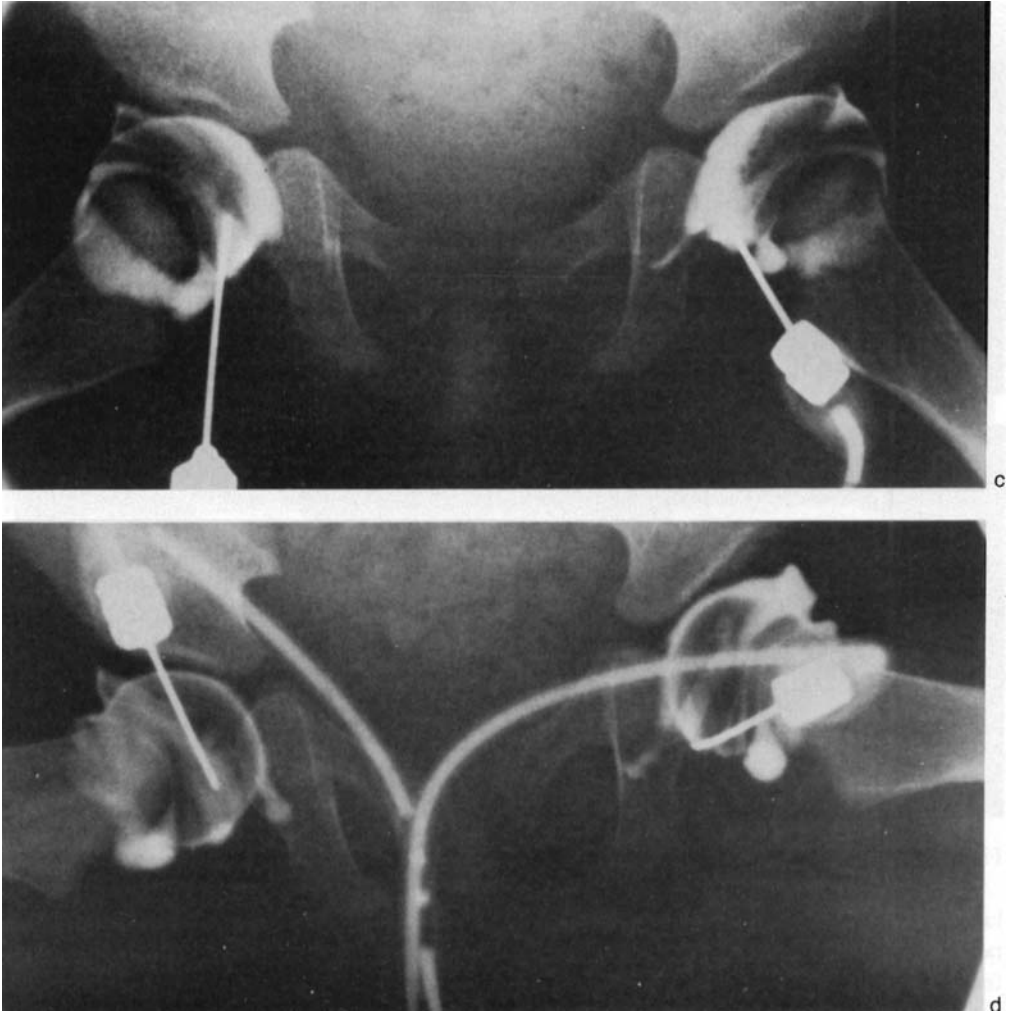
Seven-month-old girl with hip joint subluxation. a Conventional radiograph at diagnosis. Anterior-posterior view. b—d Bilateral arthrography two weeks subsequent to a period of traction, a.p. view of the pelvis. Leg position: b. 10—20° flexion and 20° inward rotation. c. 45° abduction and maximal outward rotation. d. 90° flexion and 70—80° abduction. The needles and the connecting tube are best seen in d.
